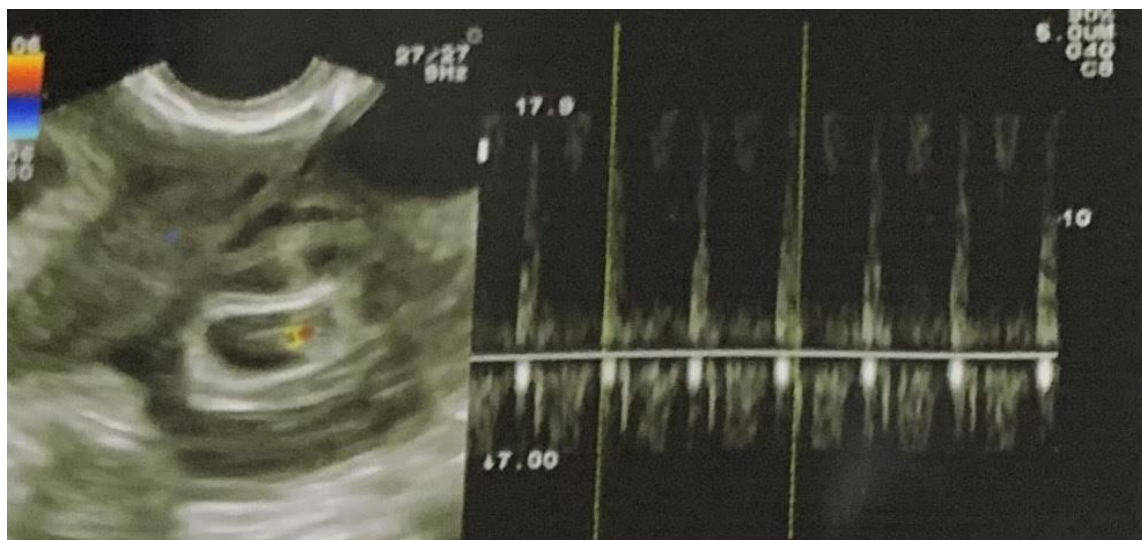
Trans vaginal ultrasonography and M mode image showing foetal heart rate in one of the gestational sac.
